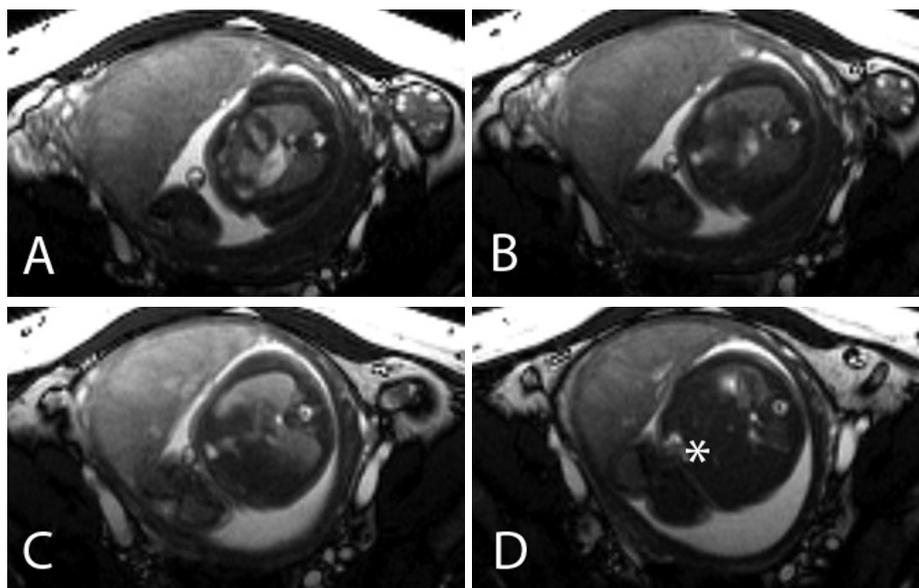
24-week-old fetal female with sirenomelia. Axial T2-weighted images demonstrate two vessel umbilical cord (A-C) and abnormal high insertion of the umbilical vein draining into right atrium (D, star).
